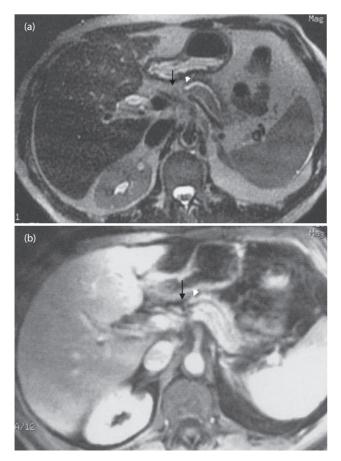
Transverse (a) non-enhanced T2-weighted MR images failed to reveal the mass (arrow), but (b) arterial phase contrast-enhanced T1-weighted magnetic resonance (MR) images revealed a hypoattenuating mass (arrow) compared to the upstream pancreatic parenchyma (arrowheads: upstream pancreatic duct dilatation).
